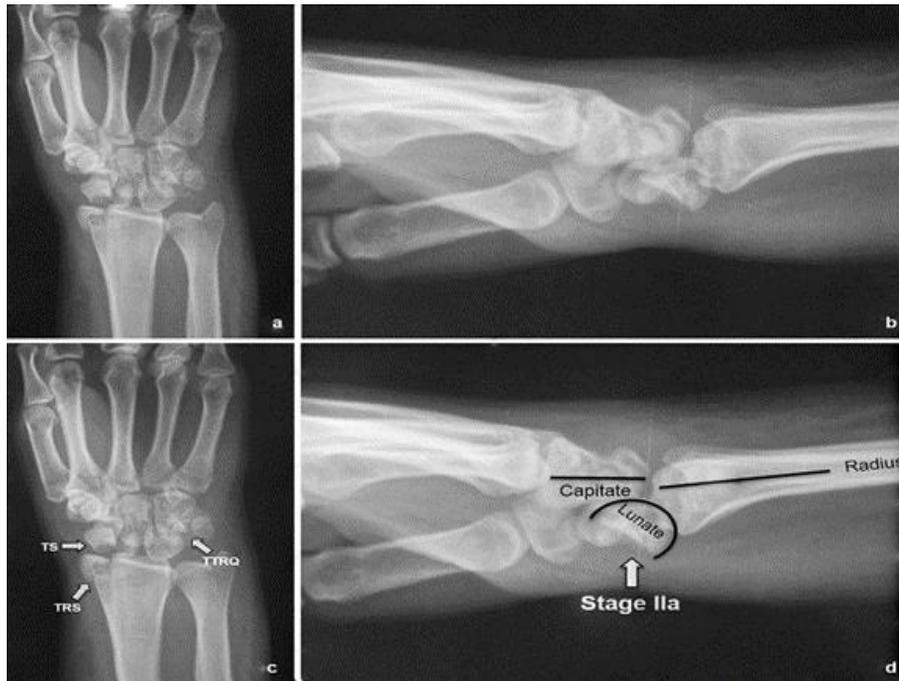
a, b. AP and lateral radiographs of left wrist of a 25 year-old female after fall from height. c. Trans scaphoid, trans radial-styloid, trans triquetral perilunate fracture dislocation on AP view. d. The relation between longitudinal axes of the radius and capitate. Volar dislocation of the lunate. (Herzberg Stage 2A perilunate fracture dislocation)
